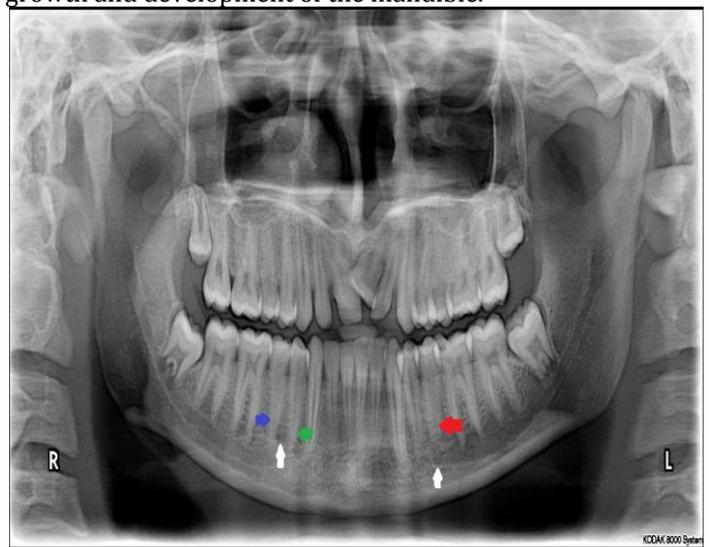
Panoramic radiograph shows asymmetrical positioning of mental foramina (white arrows), on right side it is in between first (green arrow) and second (blue arrow) while on left side, it is in line with second premolar (red arrow).
